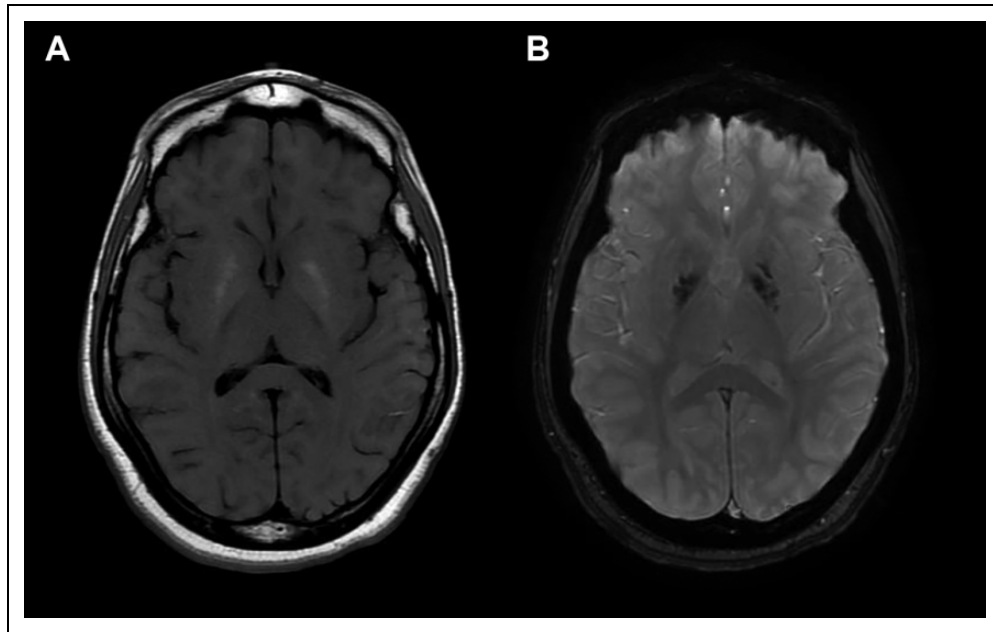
Magnetic resonance imaging of our patient's brain showing symmetric T1-hyperintense signal (A) and corresponding decreased susceptibility signal (B) within the globi pallidi bilaterally.
